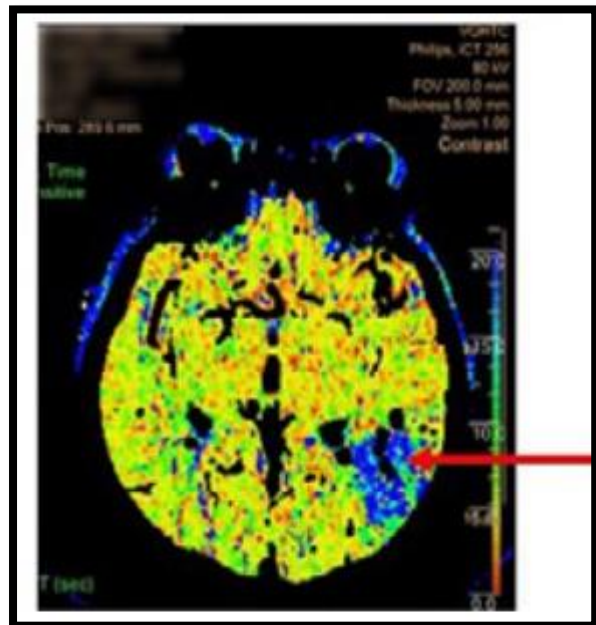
Brain CT tomography and perfusion scans on day 1 after TAVR, showing acute left temporoparietal infarction (arrows).
